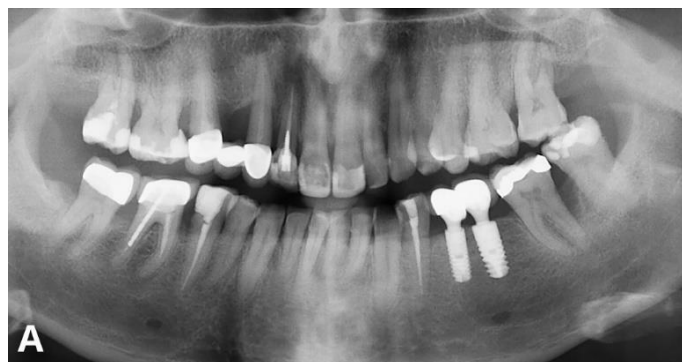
Panoramic x-rays. A – after initial periodontal therapy
